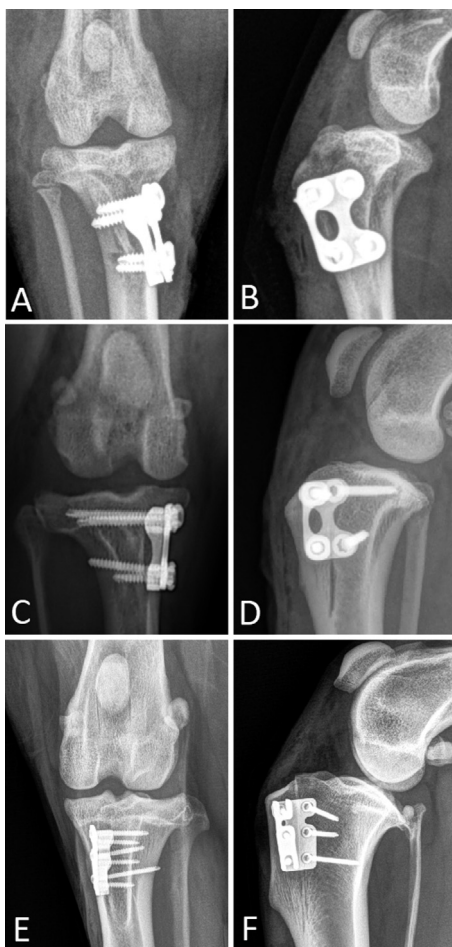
Postoperative radiographs of cases (A,B) weighing 2.45 kg, (C,D) 10.8 kg, and (E,F) 37.4 kg. Applied implants were the small four-hole plate with 2.0-mm screws in A–D and the large six-hole plate with 2.4-mm screws in E and F.
